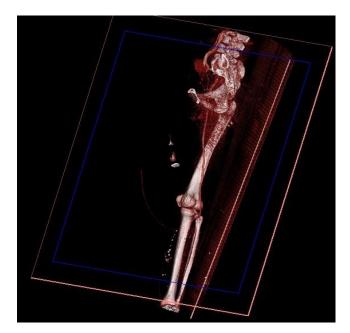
Lower extremity CT angiography in a 47-year-old female patient with a positive molecular test for COVID-19. She complained of pain and color change in the right lower limb 2 days ago. The exam demonstrated filling defects of the lower right popliteal artery and occlusion of the right sural arteries.
